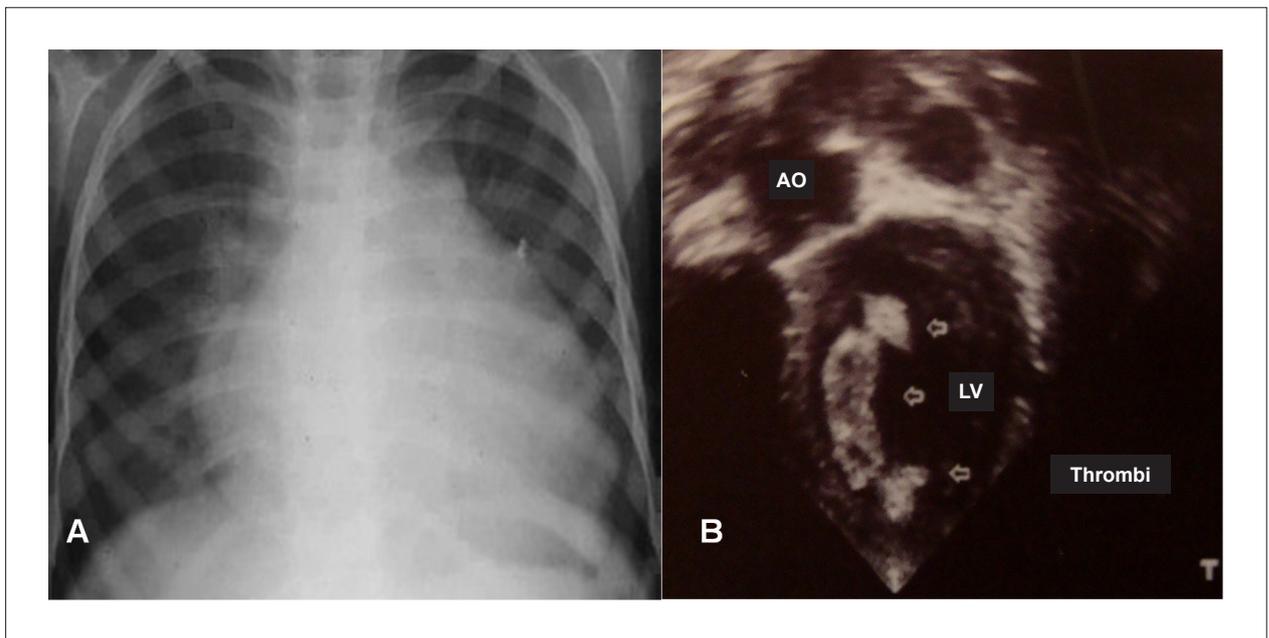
Chest radiograph (A) showing cardiomegaly, and Doppler echocardiography (B) showing left ventricular enlargement and large thrombi.
